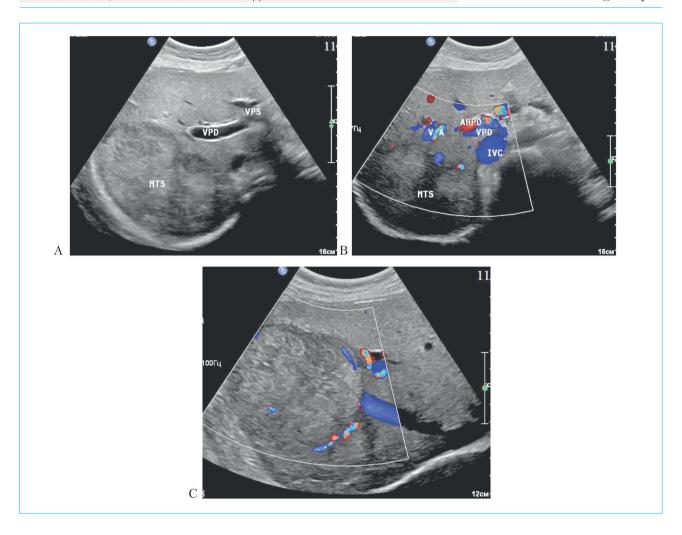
Ultrasound images of metastasis (MTS) of VI–VII liver segments: A - image in B-mode; B - Color Dop-pler Imaging, segmental veins and arteries (VA) are determined from the right branch of the portal vein (VPD) and the right own hepatic artery (AHPD), supplying the metastasis (IVC - inferior vena cava); C - Color Dop-pler Imaging, arterial and venous signals are located in the lesion structure, localized mainly at the pole, where the feeding vessels are traced
